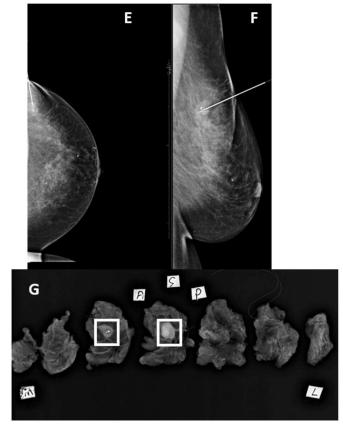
Ultrasound-Guided Needle Localization: Single Mass on Ultrasound
